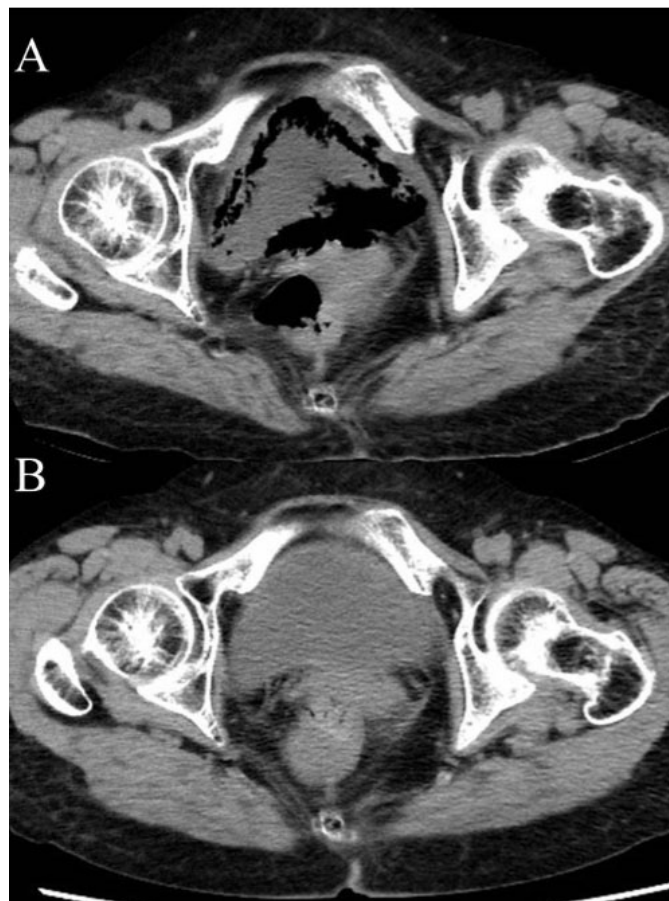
Plain abdominal CT: (A) On plain abdominal CT images, thickened bladder wall, and circumferentially gas region of bladder lumen were observed. (B) CT image four weeks after discharge showed improvement of emphysematous cystitis.
